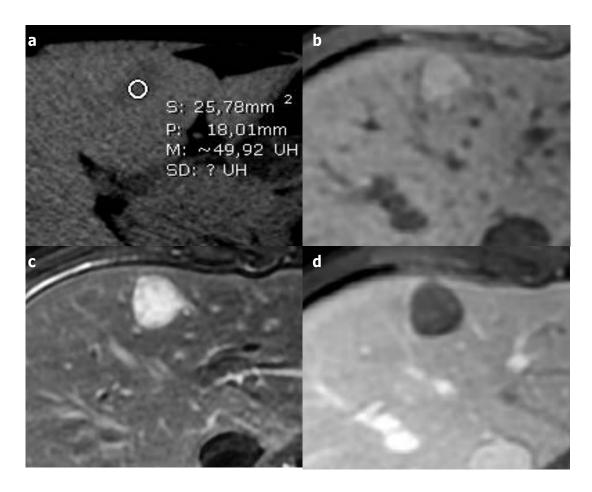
Ciliated hepatic foregut duplication cyst in a 15-year-old male patient. (a) Axial non-enhanced computed tomography shows a subcapsular nodule of the IVth segment with spontaneous attenuation around 50 Hounsfield Units. (b) At axial T1-weighted magnetic resonance imaging, it is spontaneous hyperintense. (c) It displays a high level of hyperintensity at axial T2-weighted magnetic resonance imaging. (d) Axial portal-venous phase T1-weighted magnetic resonance imaging shows neither enhancement nor wall thickening.
